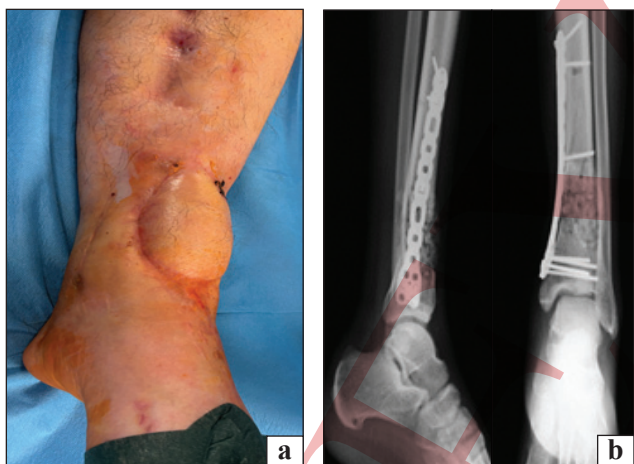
External appearance of the injured limb (a); radiographic images after SCT bone grafting (b)
